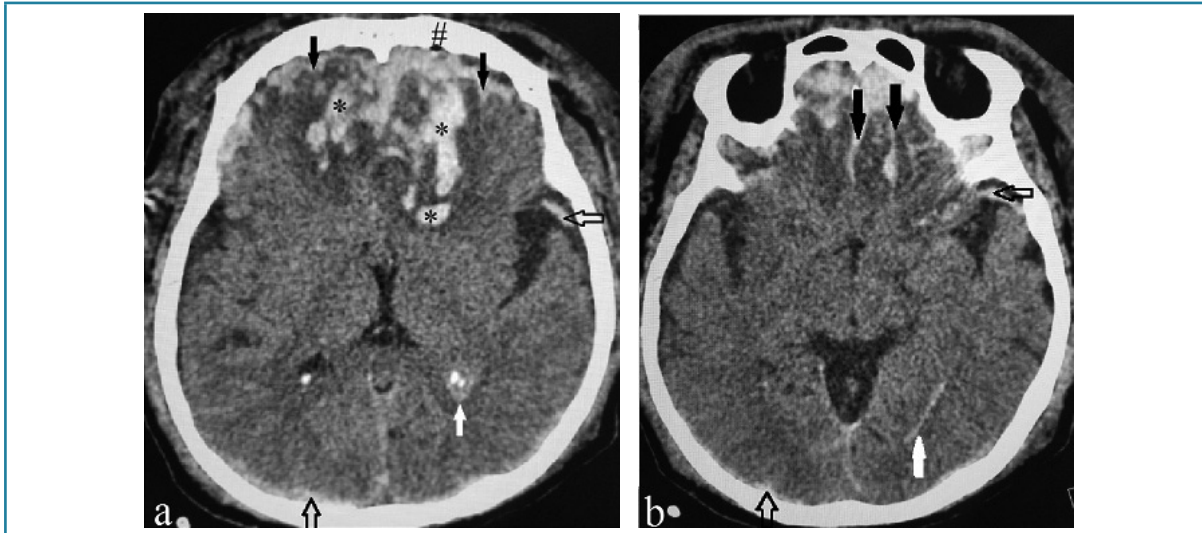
Different types of intracranial hemorrhages in non-contrast axial CT images of 44 years old male after RTA (a) at the level of atrium of lateral ventricle and (b) at the level of occipital horns, demonstrate subarachnoid hemorrhages (black arrows) and contusion/intracerebral hematoma (*) in bi frontal lobes, SDH (transparent arrows) in left temporal and right occipital region, pneumocephalous (#) in left frontal region, intraventricular hemorrhage (white arrows) in atrium and occipital horn of left side. The surrounding low attenuation around intracerebral hematoma is due to vasogenic edema. Frontal horns of both sides are effaced due to edema/mass effects
